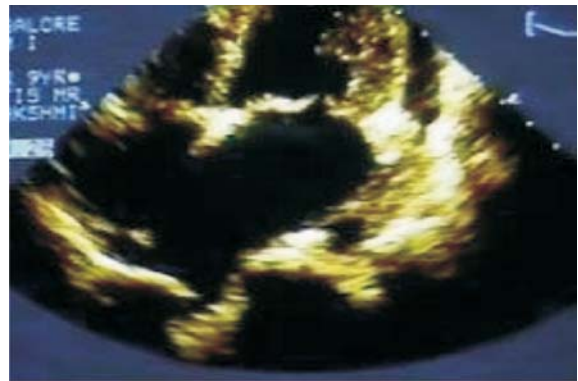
10 years old girl with Mitral regurgitation. Apical four chamber view shows MVP, PE, MR with chordal tear ECHO Score-10 (MVP-2,MR-2, MV thick-2, PE-2 Chordal tear-2).
